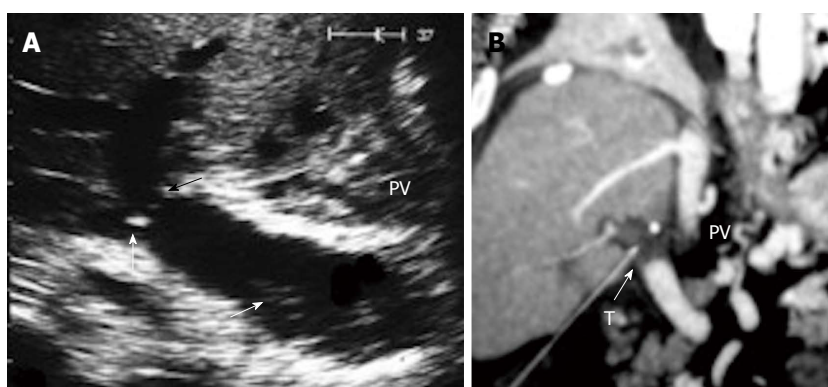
Post-operative portal vein thrombosis, 1 wk post-living donor liver transplantation. A: B-mode US image showing faintly echogenic thrombus in the recipient PV (arrow) and PV anastomotic stricture (arrow heads); B: Multi-slice CT angiography, coronal reconstructed image after 2 h, demonstrating total PV thrombosis (arrow). The patient underwent thrombectomy and anastomotic revision. PV: Portal vein; T: Thrombus.
